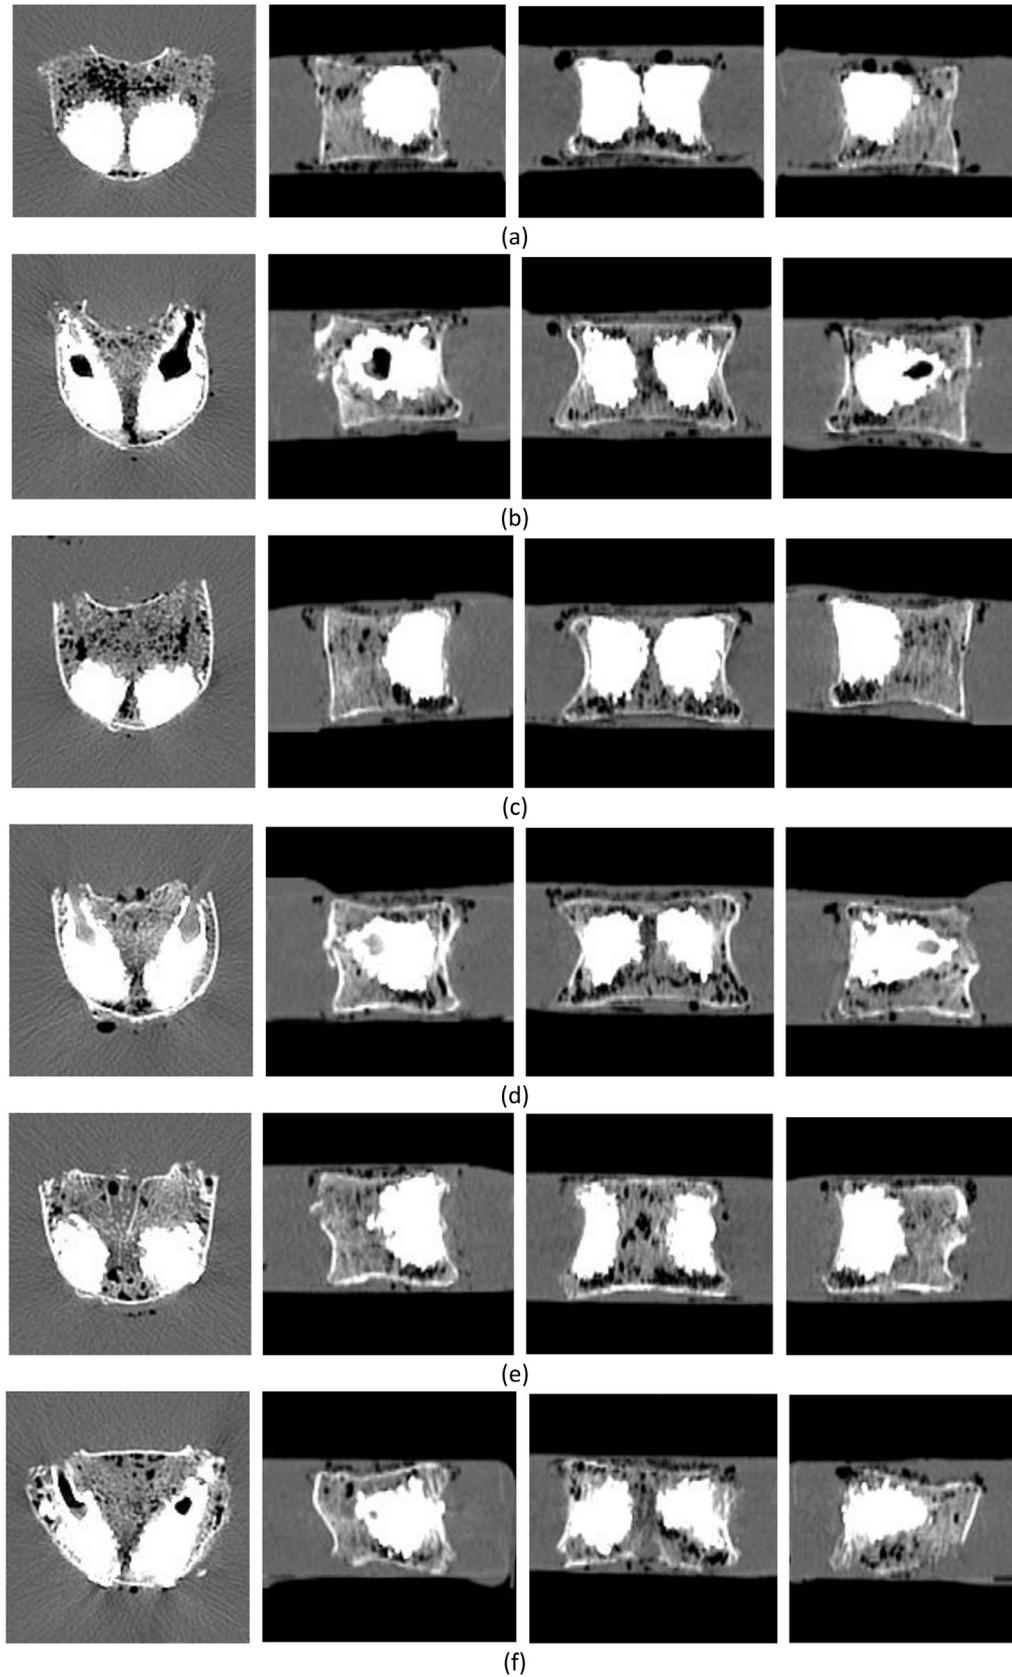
CT slices after the compression test of the same lumbar spine segments shown in Fig. 1. Series of transverse, left sagittal, coronal and right sagittal (from left to right) sections: (a) T12, VP; (b) L1, KP; (c) L2, VP; (d) L3, KP; (e) L4, VP; (f) L5, KP. T refers to thoracic, L to lumbar, VP to vertebroplasty and KP to kyphoplasty.
